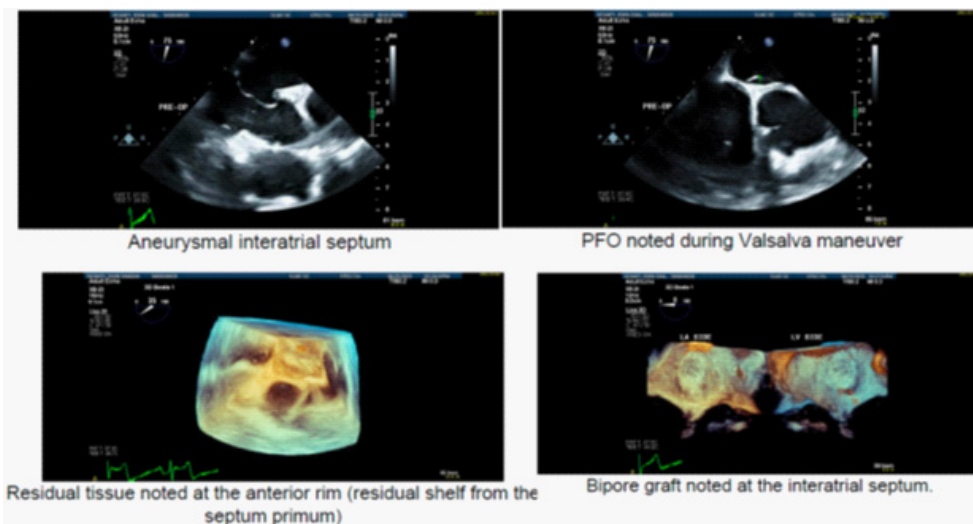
Transesophageal echocardiography findings preoperative (above) and postoperative (below).
